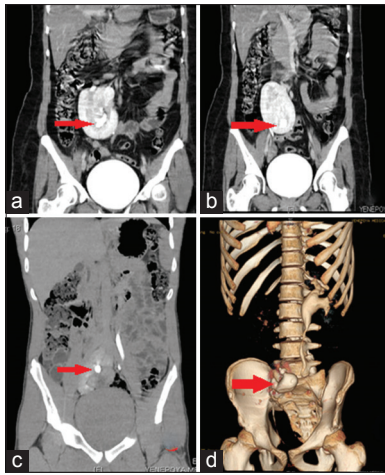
Patients demographics. (a-c) Coronal sections of plain computed tomography of patients showing ectopic kidney with the stones (arrow). (d) Three-dimensional reconstruction of the patient shown in Figure 1c, after contrast injection (excretory phase), showing both functional kidneys
